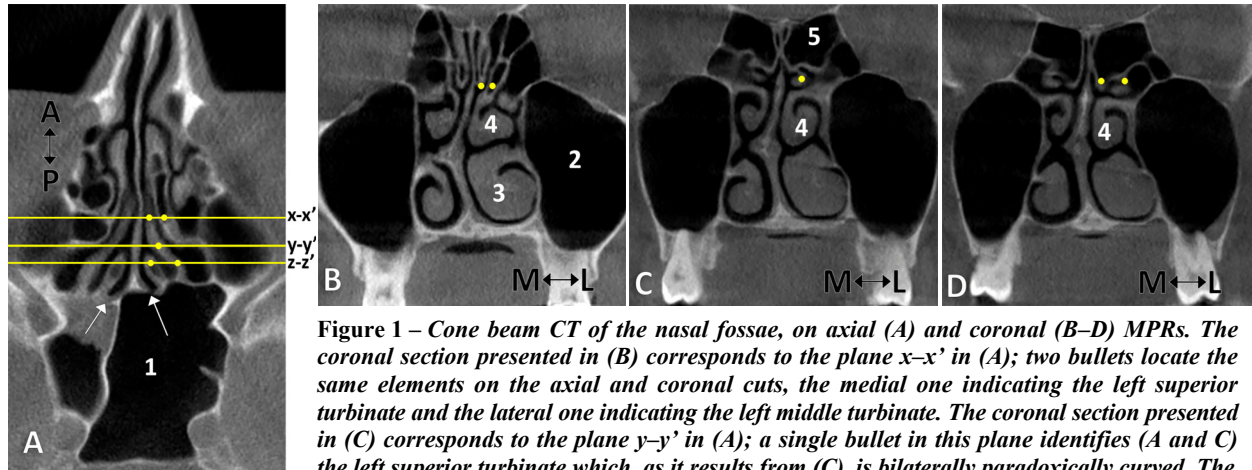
Cone beam CT of the nasal fossae, on axial (A) and coronal (B–D) MPRs. The coronal section presented in (B) corresponds to the plane $x-x'$ in (A); two bullets locate the same elements on the axial and coronal cuts, the medial one indicating the left superior turbinate and the lateral one indicating the left middle turbinate. The coronal section presented in (C) corresponds to the plane $y-y'$ in (A); a single bullet in this plane identifies (A and C) the left superior turbinate which, as it results from (C), is bilaterally paradoxically curved. The coronal section presented in (D) corresponds to the plane $z-z'$ in (A); two bullets locate the same elements on the axial and coronal cuts, the medial one indicating the left supreme turbinate and the lateral one indicating the left superior turbinate. M: Medial; L: Lateral; A: Anterior; P: Posterior. The arrows in (A) indicate the ostia of the sphenoidal sinuses. 1: Left sphenoidal sinus; 2: Left maxillary sinus; 3: Left inferior turbinate; 4: Left middle turbinate; 5: Posterior ethmoid air cell.
